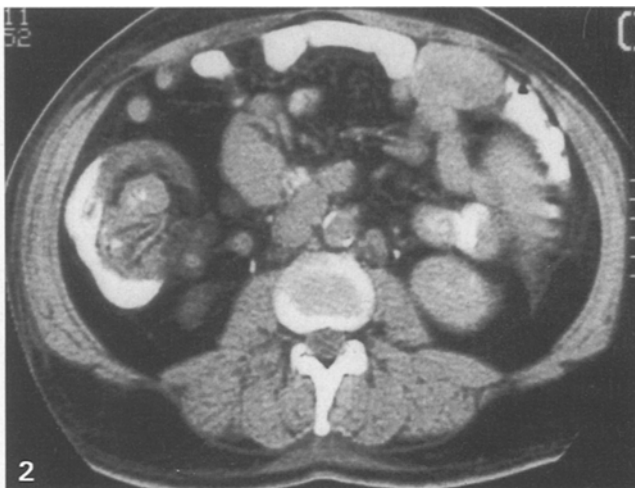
CT of pelvic region showing leash of distorted centrally placed vessels associated with colocolic intussusception (see Fig. 4).
